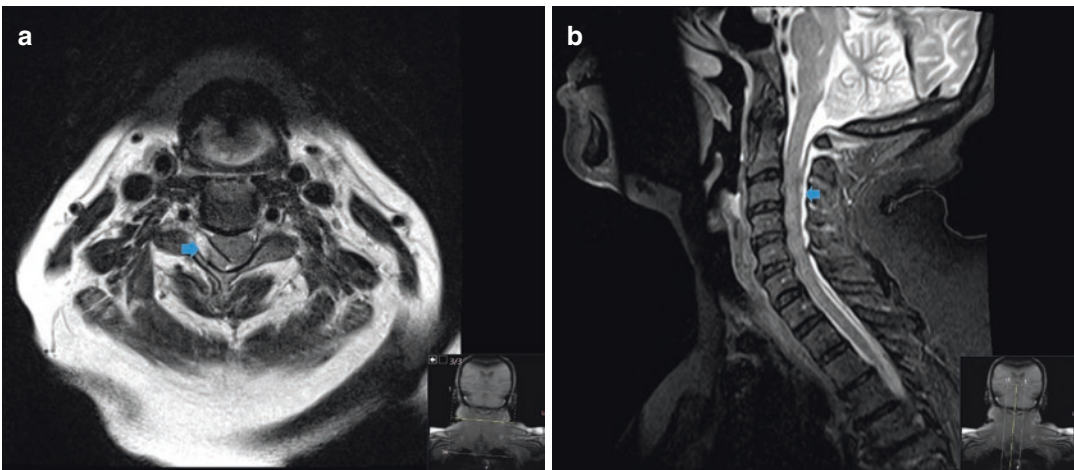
Epidural hematoma Figure 9.5a is an axial T2-weighted MR image through the cervical spine, showing a heterogeneous dorsal epidural hematoma at the right dorsolateral aspect of the spinal canal causing mass effect
